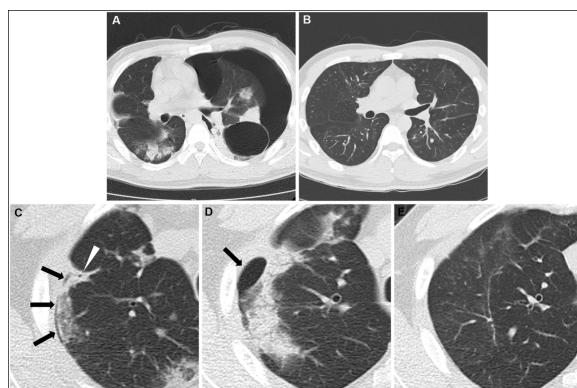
Typical chest computed tomography manifestations at different time points. Day 21, pneumothorax was found on the left side with a subpleural giant bulla (A), which was completely absorbed on day 92 (B). Day 21, a subpleural hypodense line (B, black arrows) was noticed in the right upper lung attaching to a branch of a peripheral bronchus (C, white arrowhead) surrounded with consolidation; day 24, the previous subpleural hypodense line became a localized pneumothorax (D, black arrow); day 92, the localized pneumothorax was completely absorbed (E). All images have the same window level of -600 and window width of 1600.
